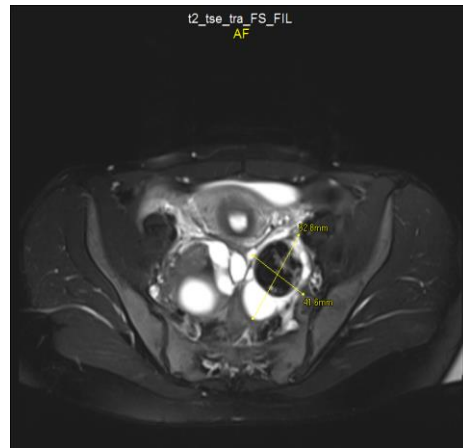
MRI examination. The Left Ovary
